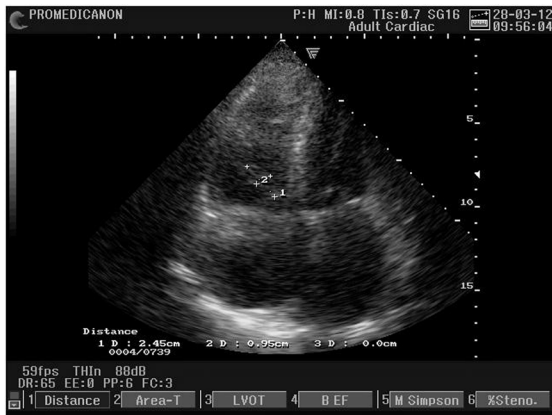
Transthoracic echocardiography image (apical view of 4 chambers) of vegetation attached to the septal tricuspid valve.
